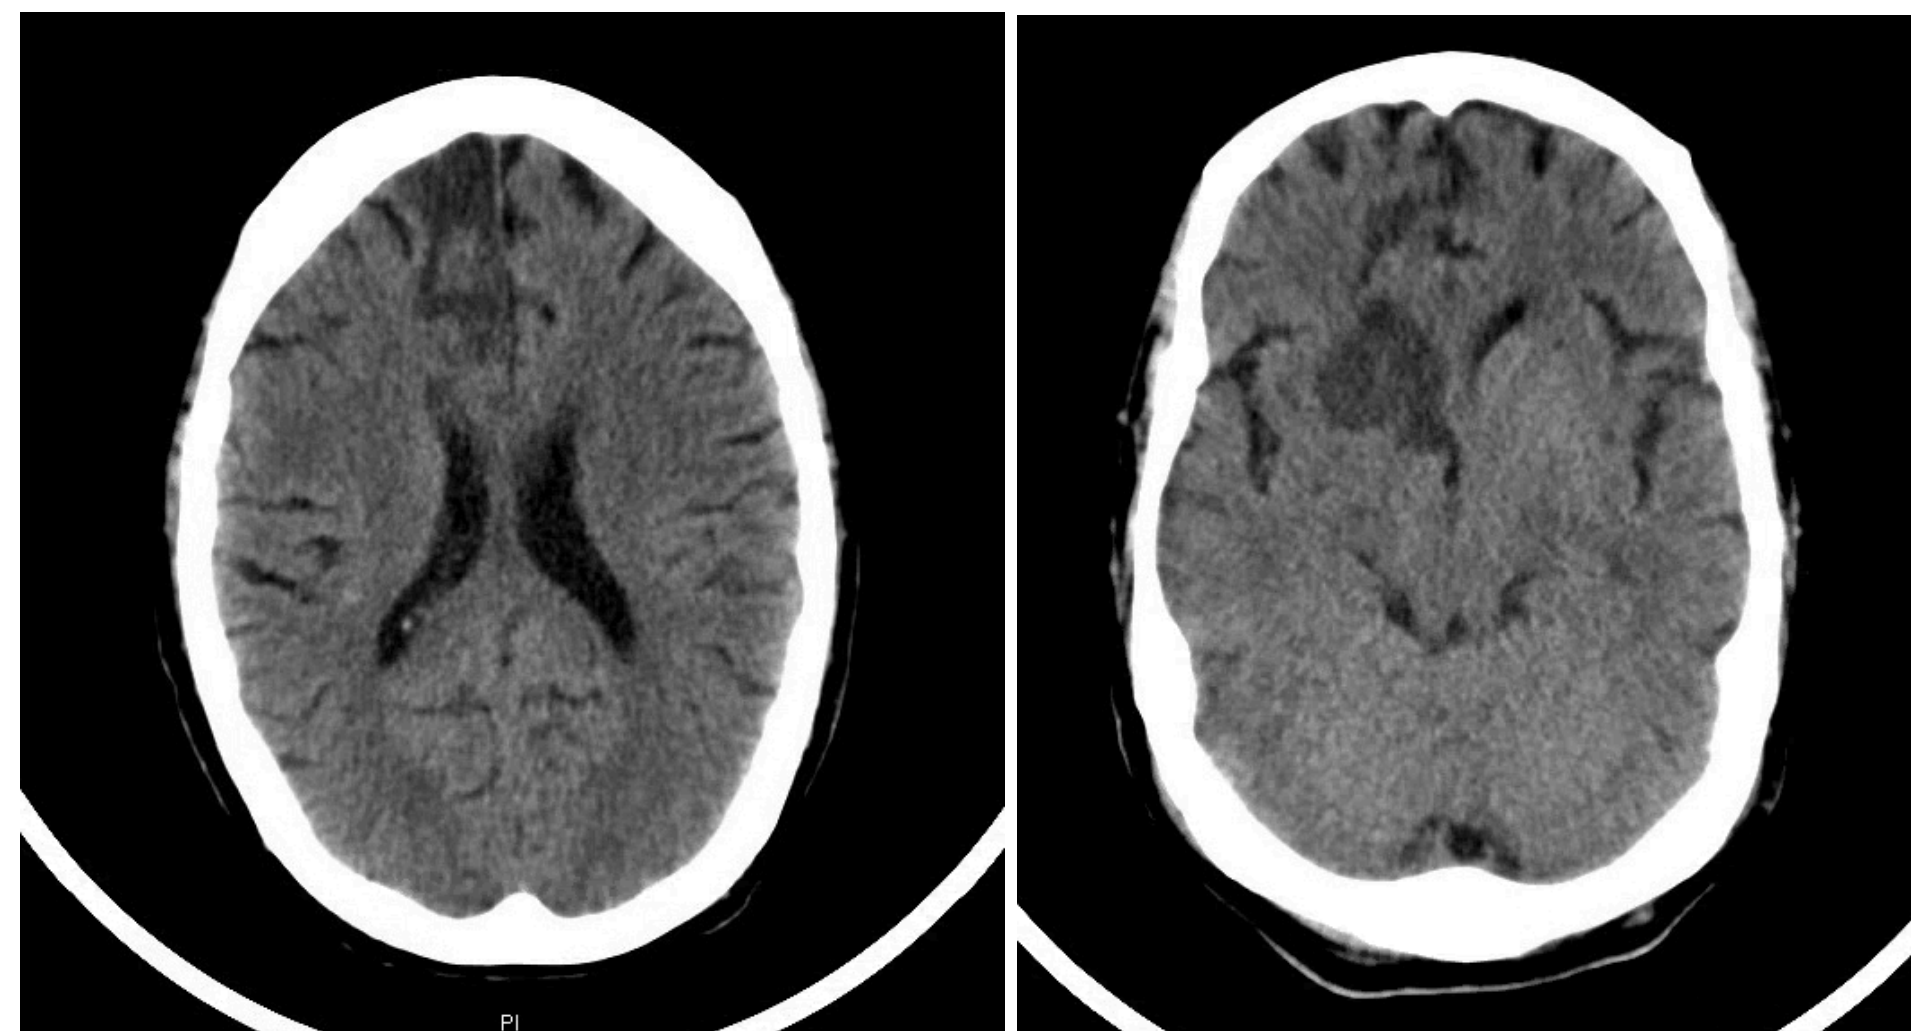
Patient 3 CT head showing R frontal and basal ganglia acute infarct likely due to intracranial atherosclerosis, but hypercoagulable state can be contributory.
